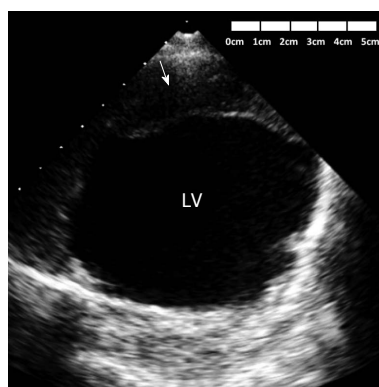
Transthoracic echocardiogram using parasternal short axis view at the midventricular level showing the thrombus (arrow) covering the anterior wall aneurysm. LV: Left ventricle.
